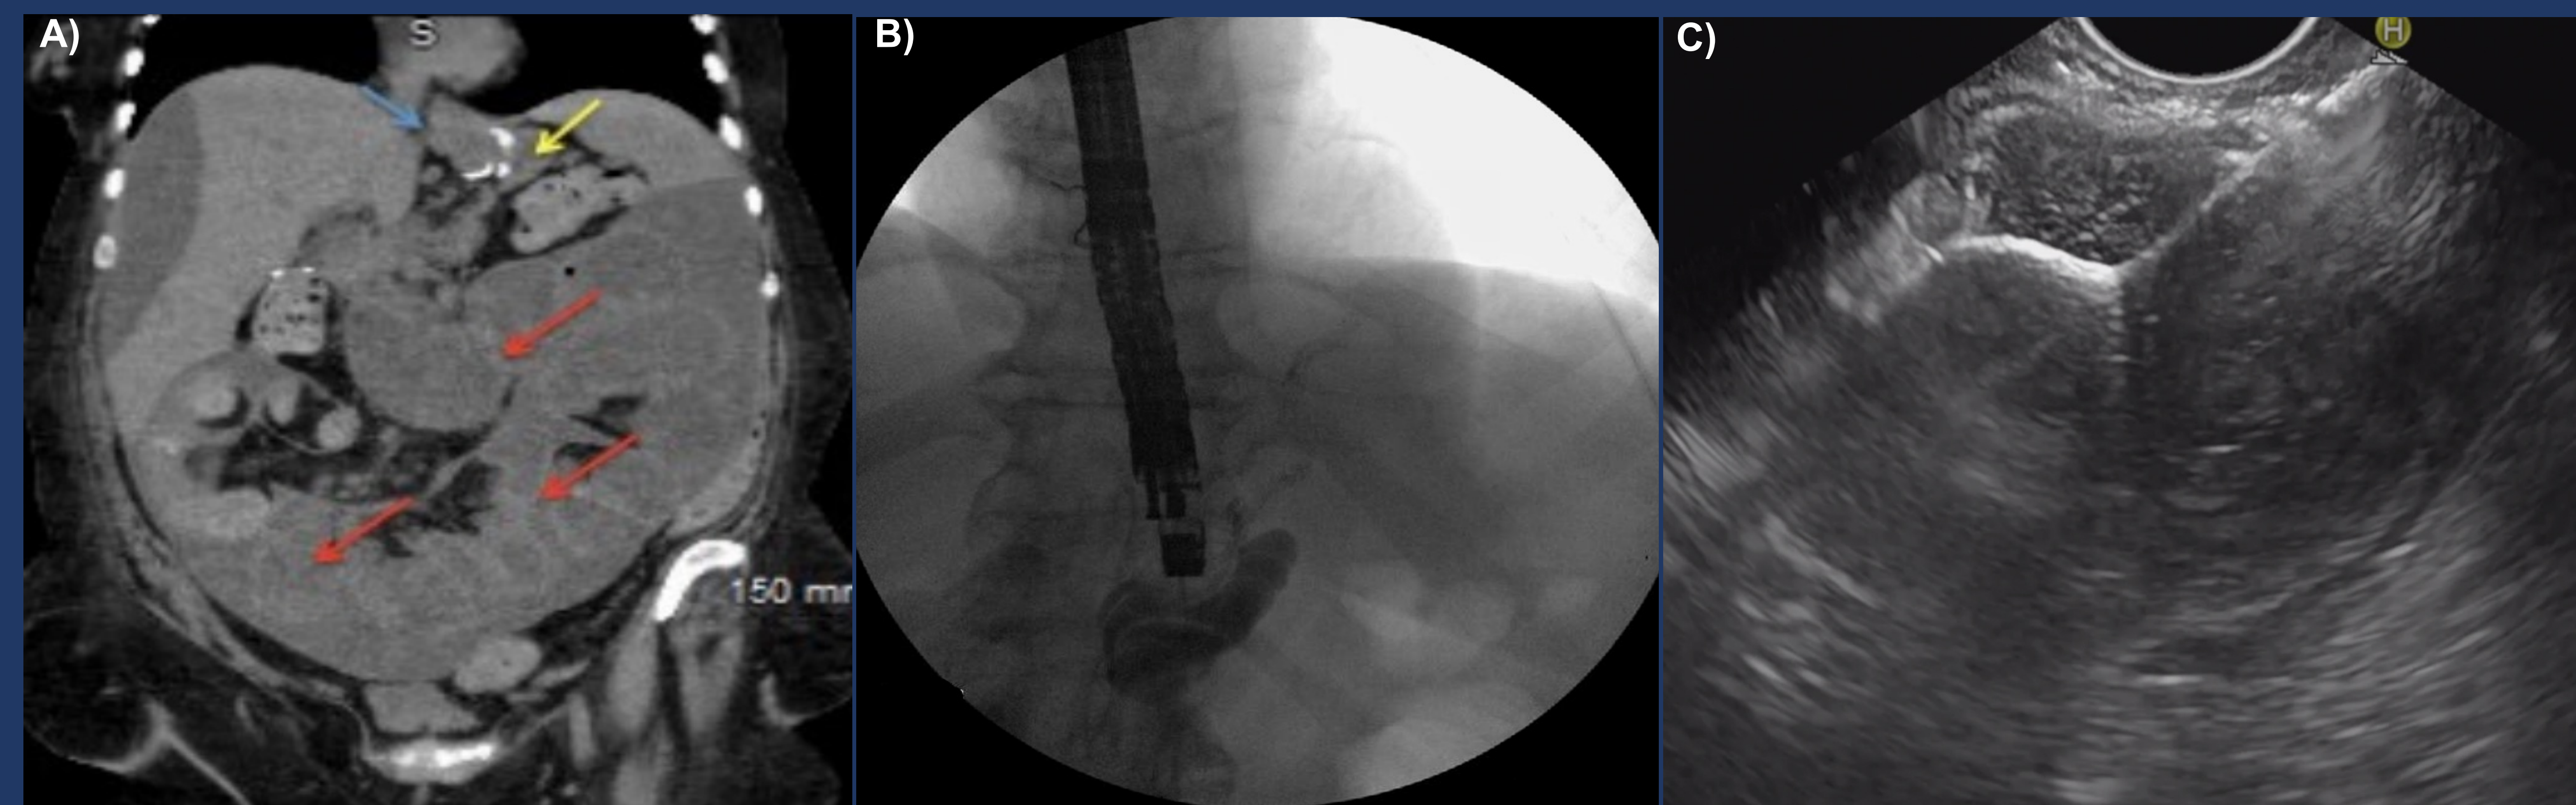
A) Computed tomography scan demonstrating dilated gastric pouch (Blue arrow), dilated bypassed stomach (Yellow arrow) and multiple dilated distal loops of small bowel (Red arrows) B) Expansion of bypassed stomach with a mixture of saline and ionic contrast in preparation for LAMS placement under fluoroscopic and endosonographic guidance. C) Echoendoscopic view of deployment of an electrocautery-enhanced 20x10mm LAMS into the bypassed stomach.
